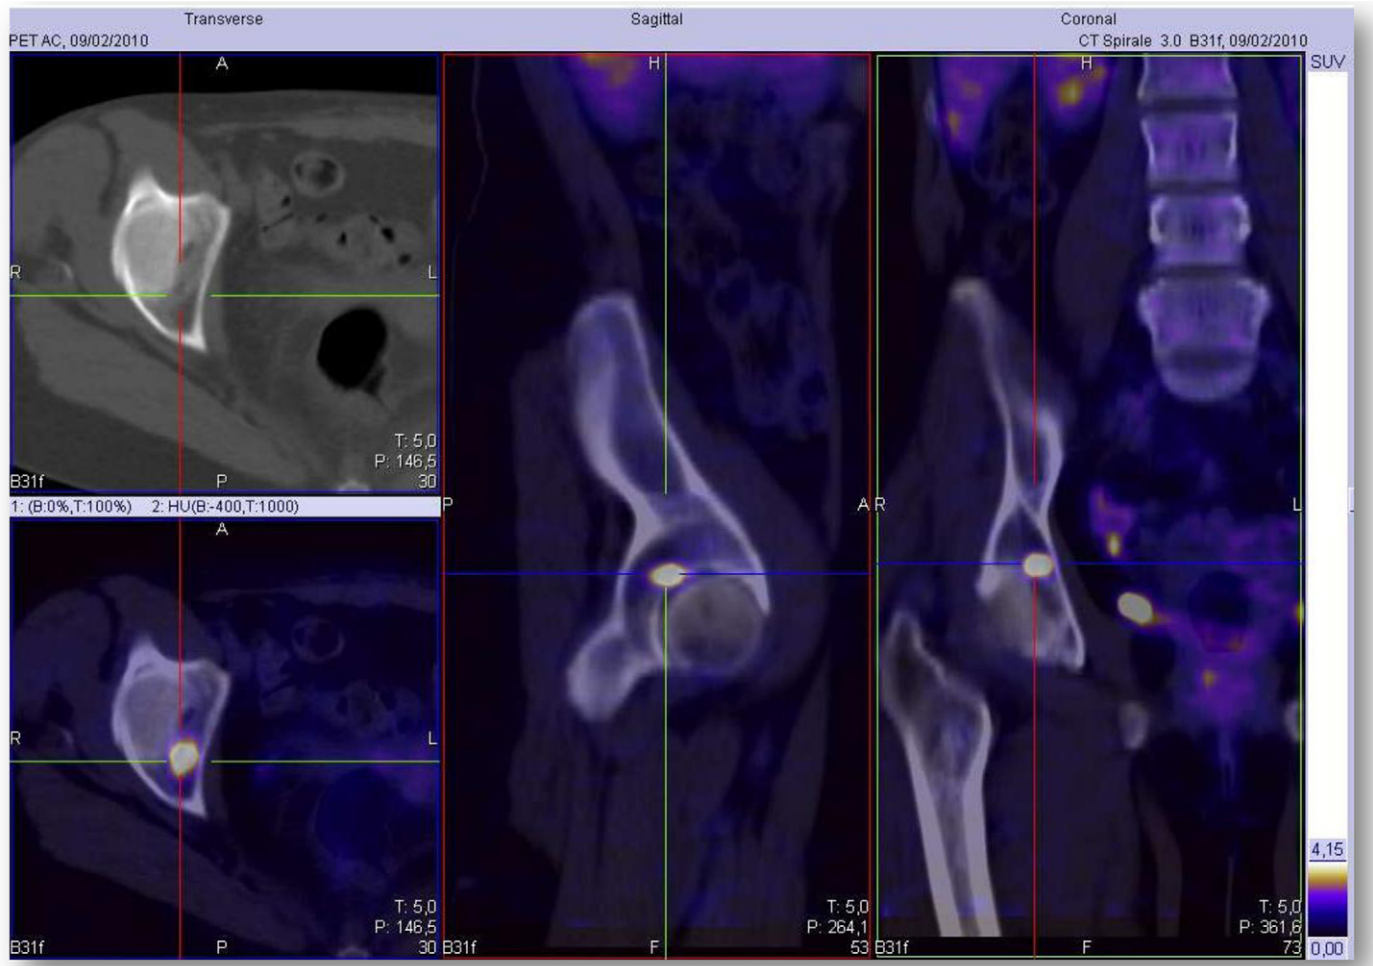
An example of a patient with a focal FDG-uptake in right ischium, compatible with bone marrow lesion.
